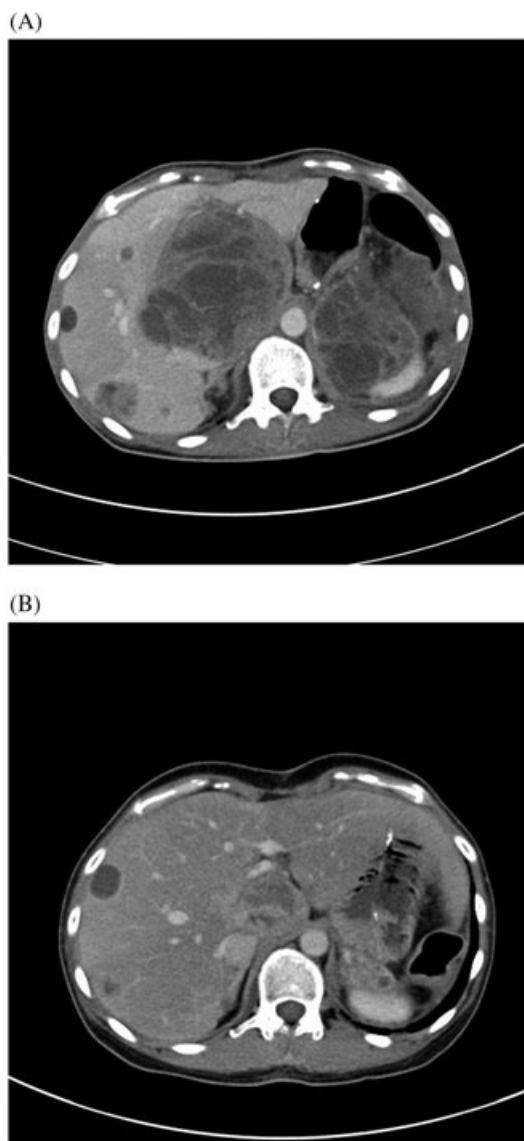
CT images of abdomen. A, Before DXR. B, After DXR
